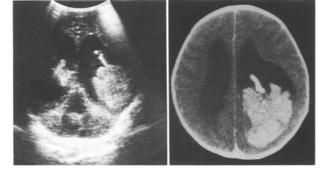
Transfontanellar ultrasound and CT Scan of left lateral ventricle papilloma in a 4 months old baby. Note the similar aspect of the tumour and the feeding artery
